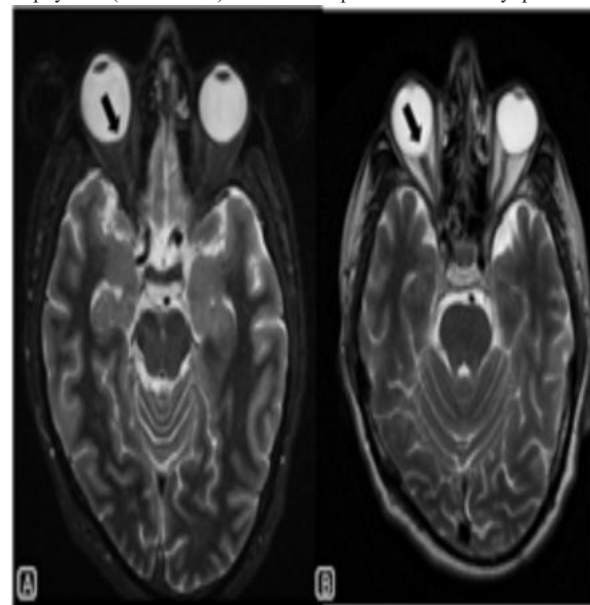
Axial T2WI of MRI brain and orbit showing macular staphyloma in right eye(black arrow).
